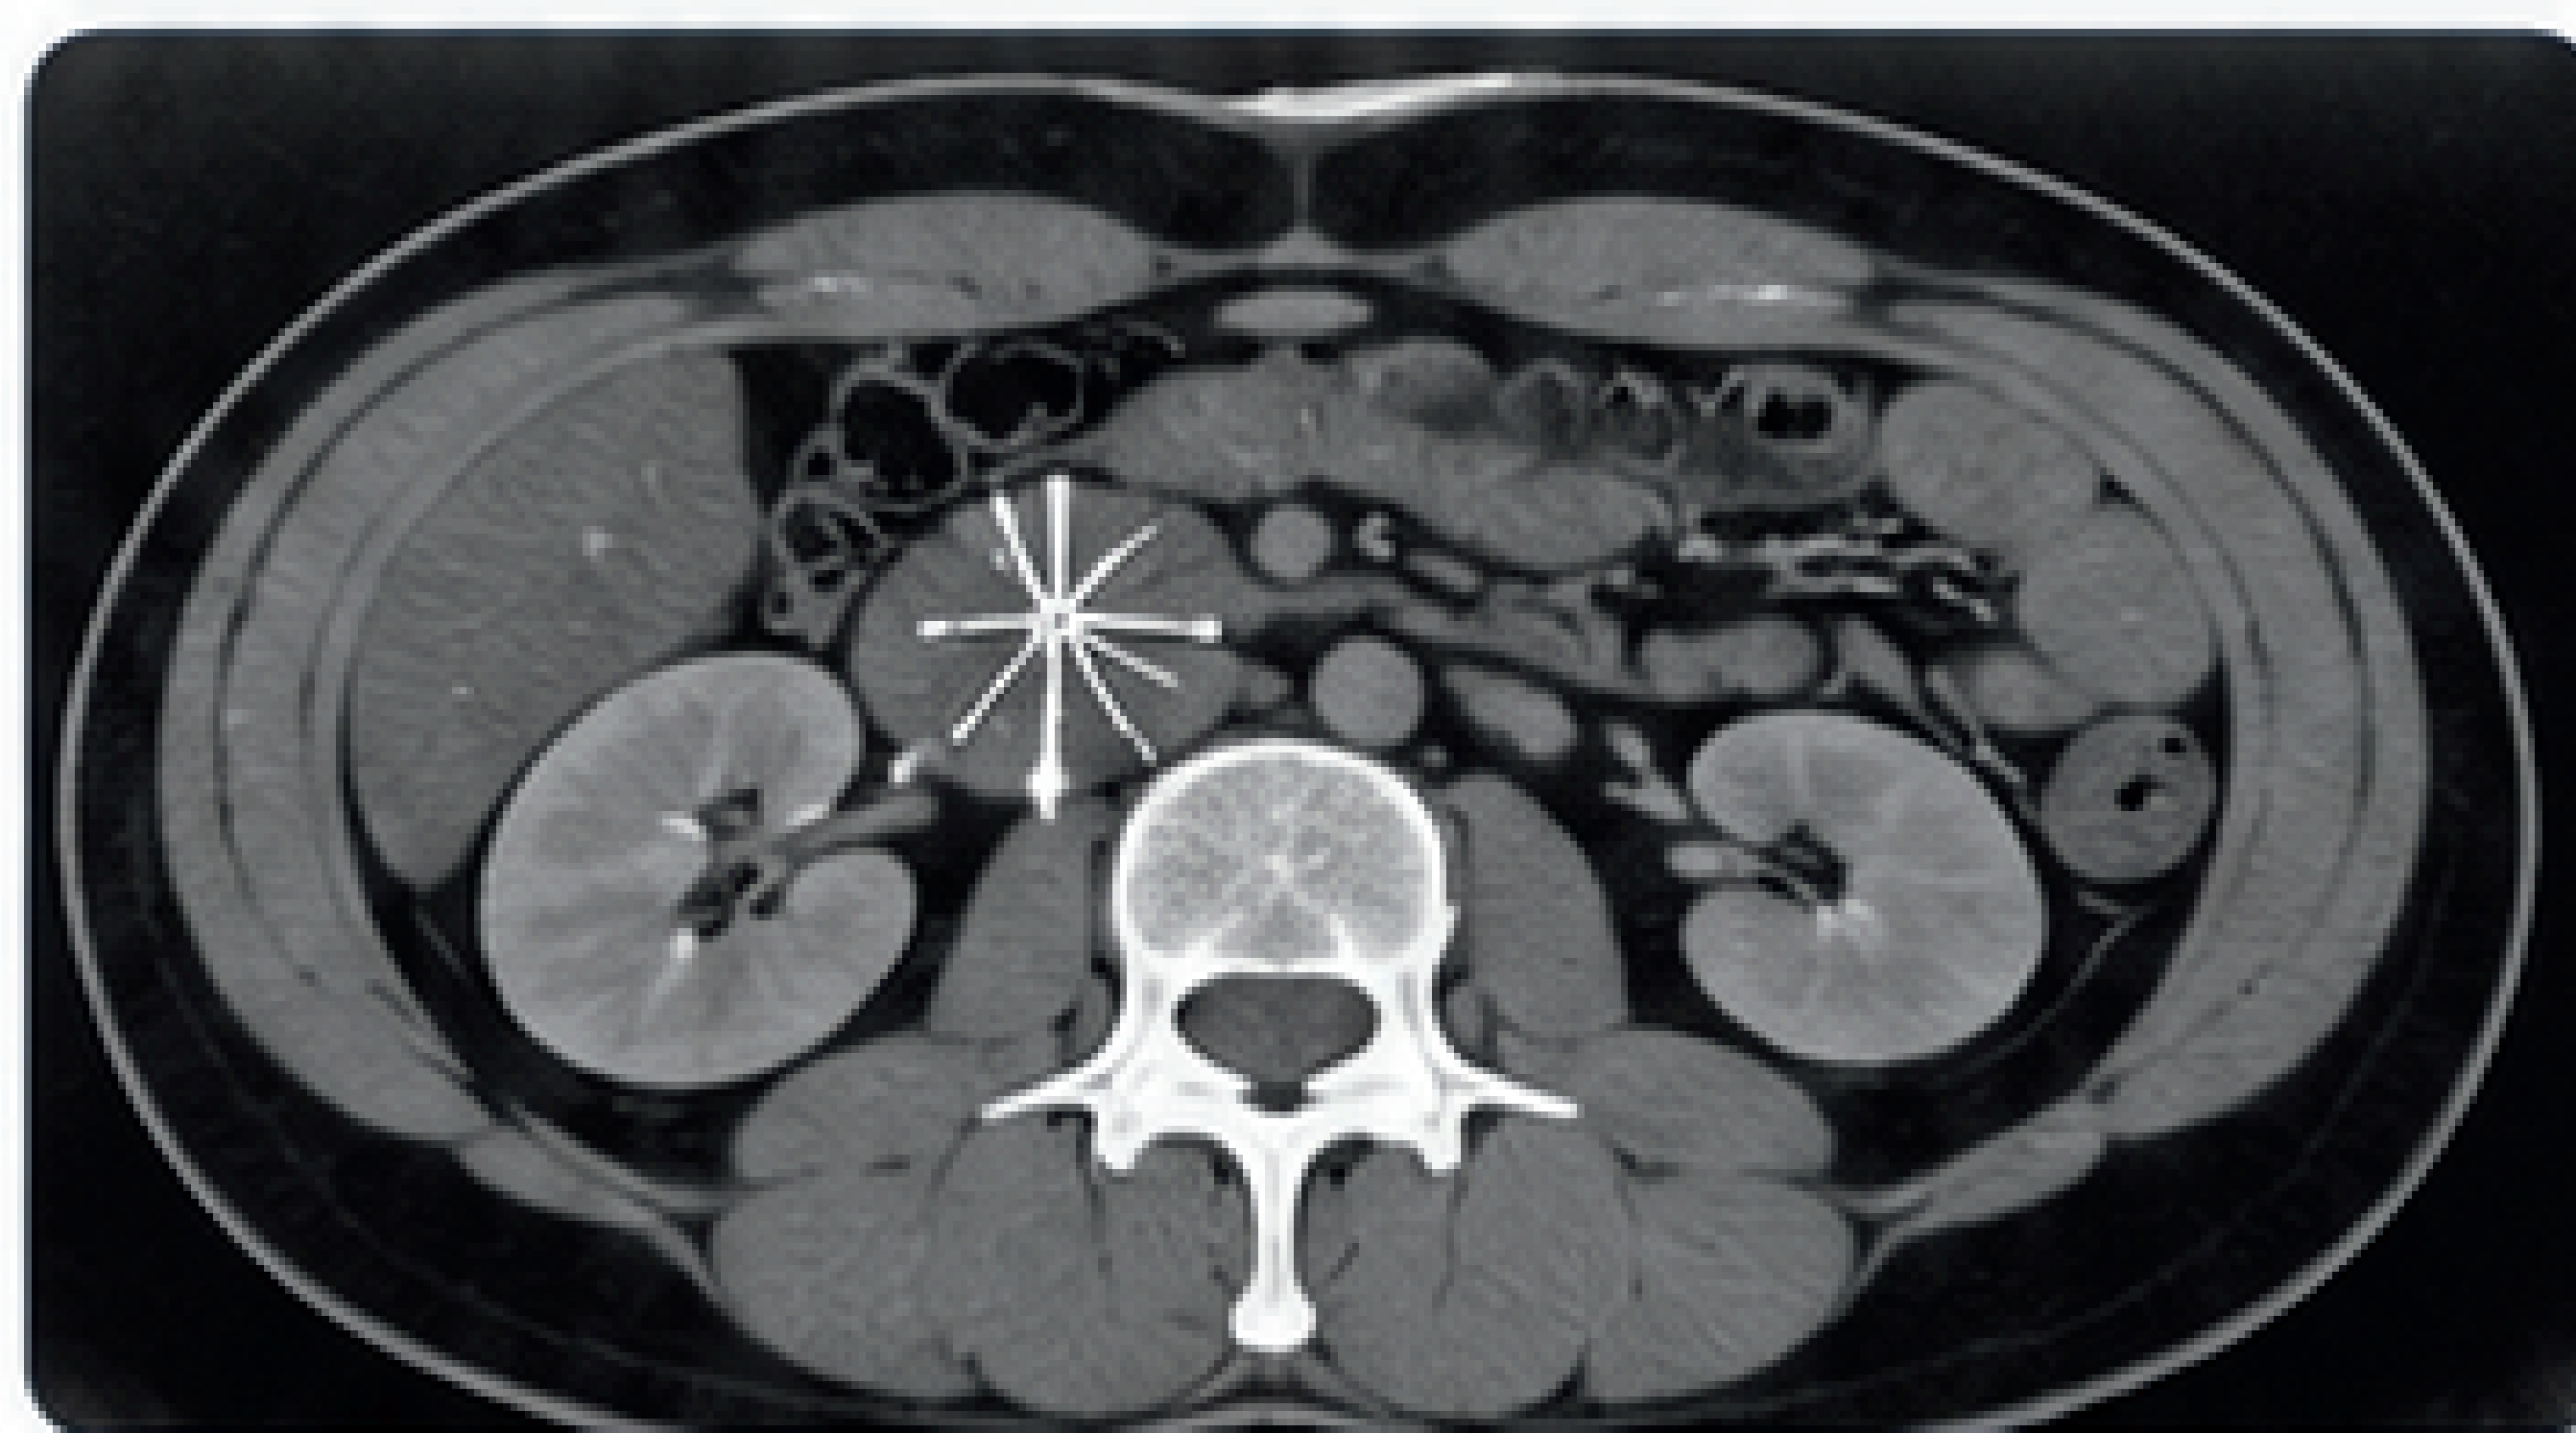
CT scan-style image showing an inferior vena cava (IVC) filter positioned within the IVC.
